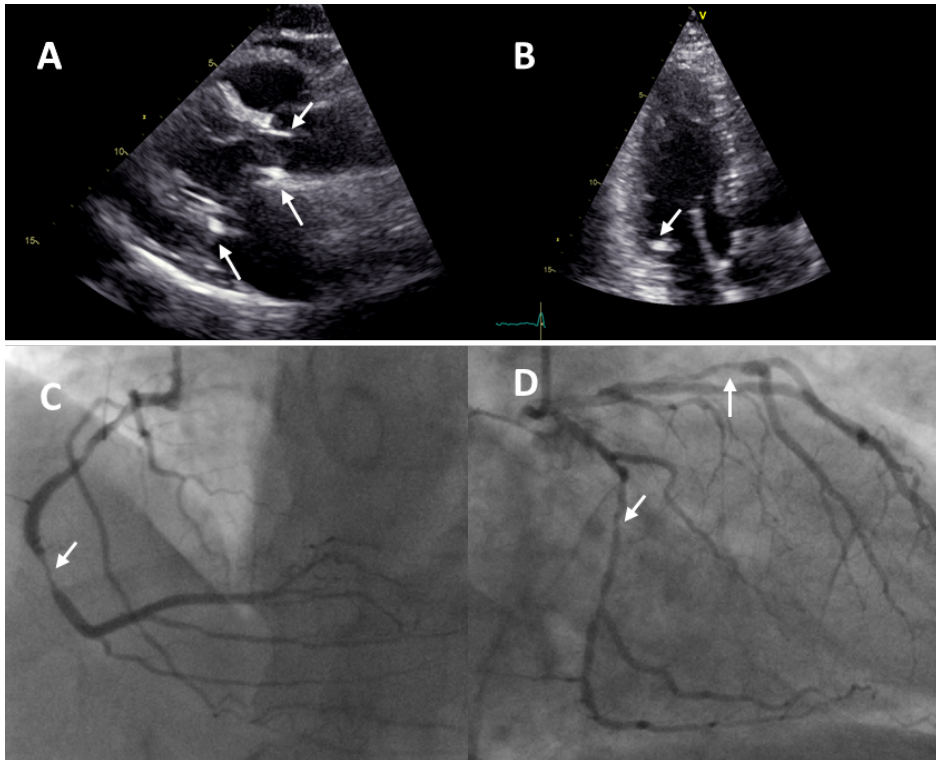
Example of a 50-year-old male with calcified posterior mitral annulus and aortic valve and 3-vessel coronary artery disease. Panel A shows the parasternal long-axis view of the left ventricle with calcification of the aortic valve (arrows) and the posterior annulus of the mitral valve (arrow). Panel B shows the apical long-axis view of the left ventricle and calcified posterior mitral annulus (arrow). Panel C shows the right coronary artery with a significant lesion of the mid segment (arrow) and panel D shows the left coronary system with significant lesions in the circumflex coronary artery and first diagonal branch of the left anterior descending coronary artery (arrows).
